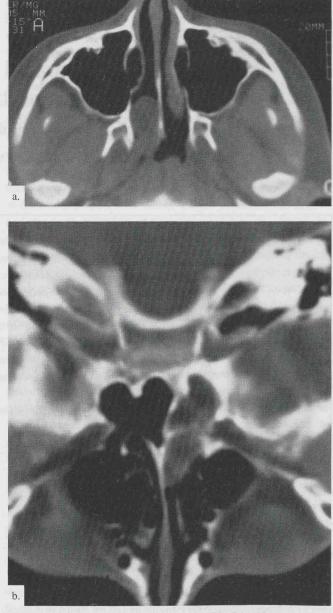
Case 2: Axial CT-section showing the right sphenoid sinus to be filled with soft tissue, and a small polyp was present in the right part of the epipharynx. Ethmoidal sinuses and maxillary sinus are normal
